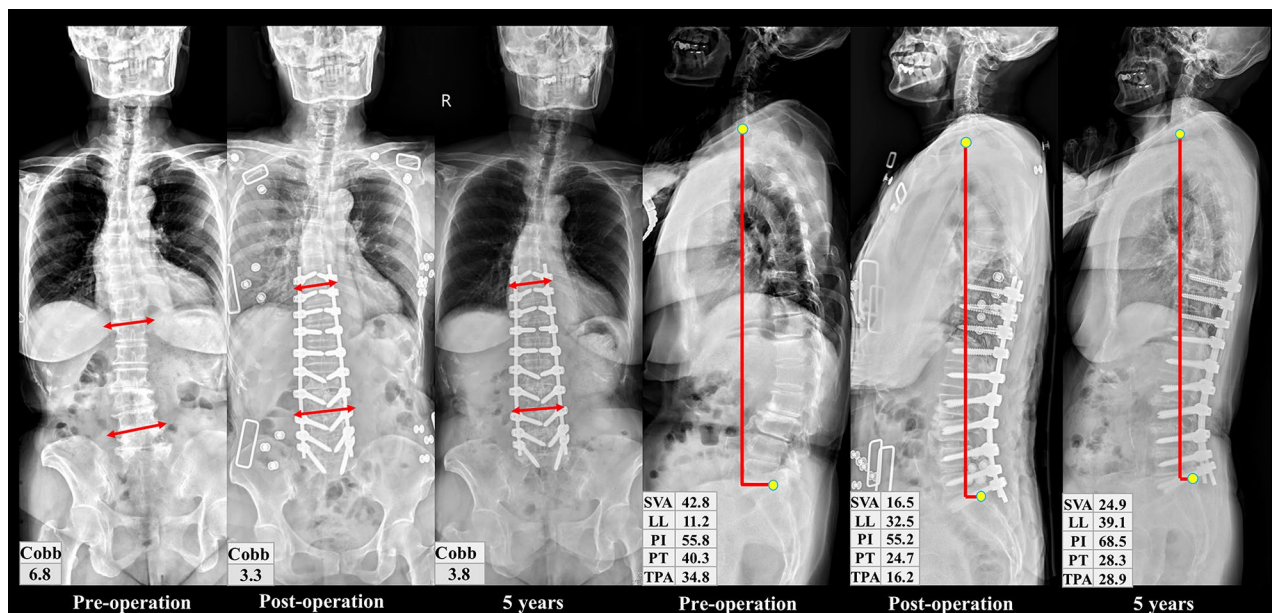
A 72-year-old female with ASD from multiple degenerative disc diseases underwent PPS correction. X-rays showed satisfactory sagittal plane correction, maintained at the 5-year follow-up
